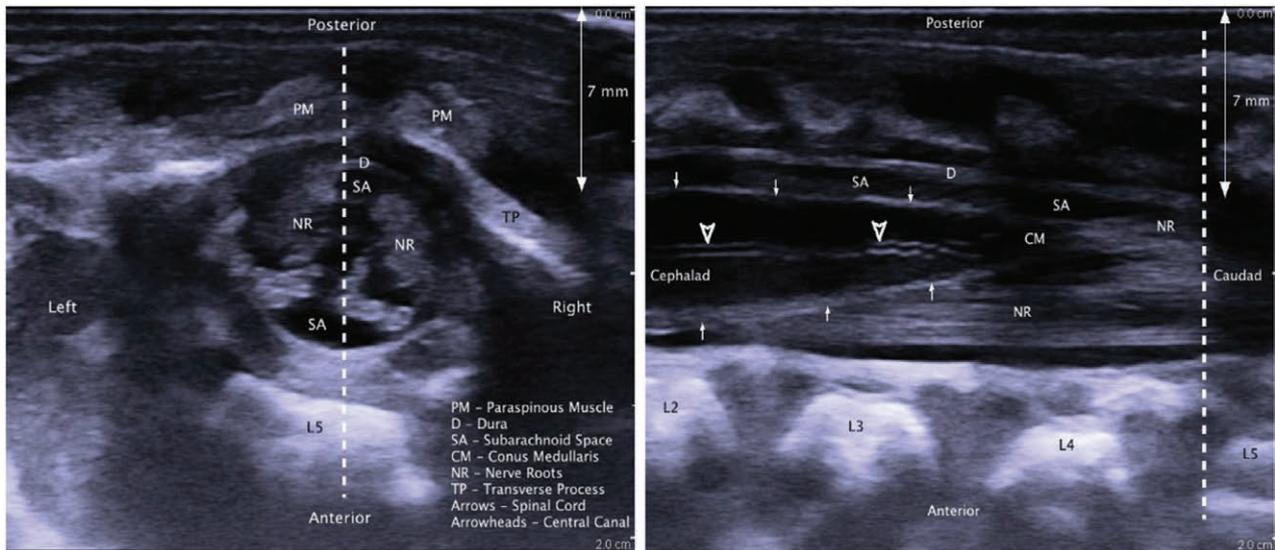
Images in Anesthesiology: Use of Ultrasound to Facilitate Neonatal Spinal Anesthesia
